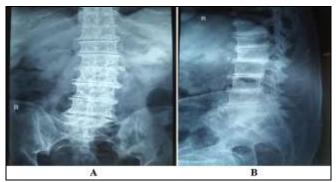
Radiographic Images of Spine (a) Antero-posterior View (b) Lateral View
